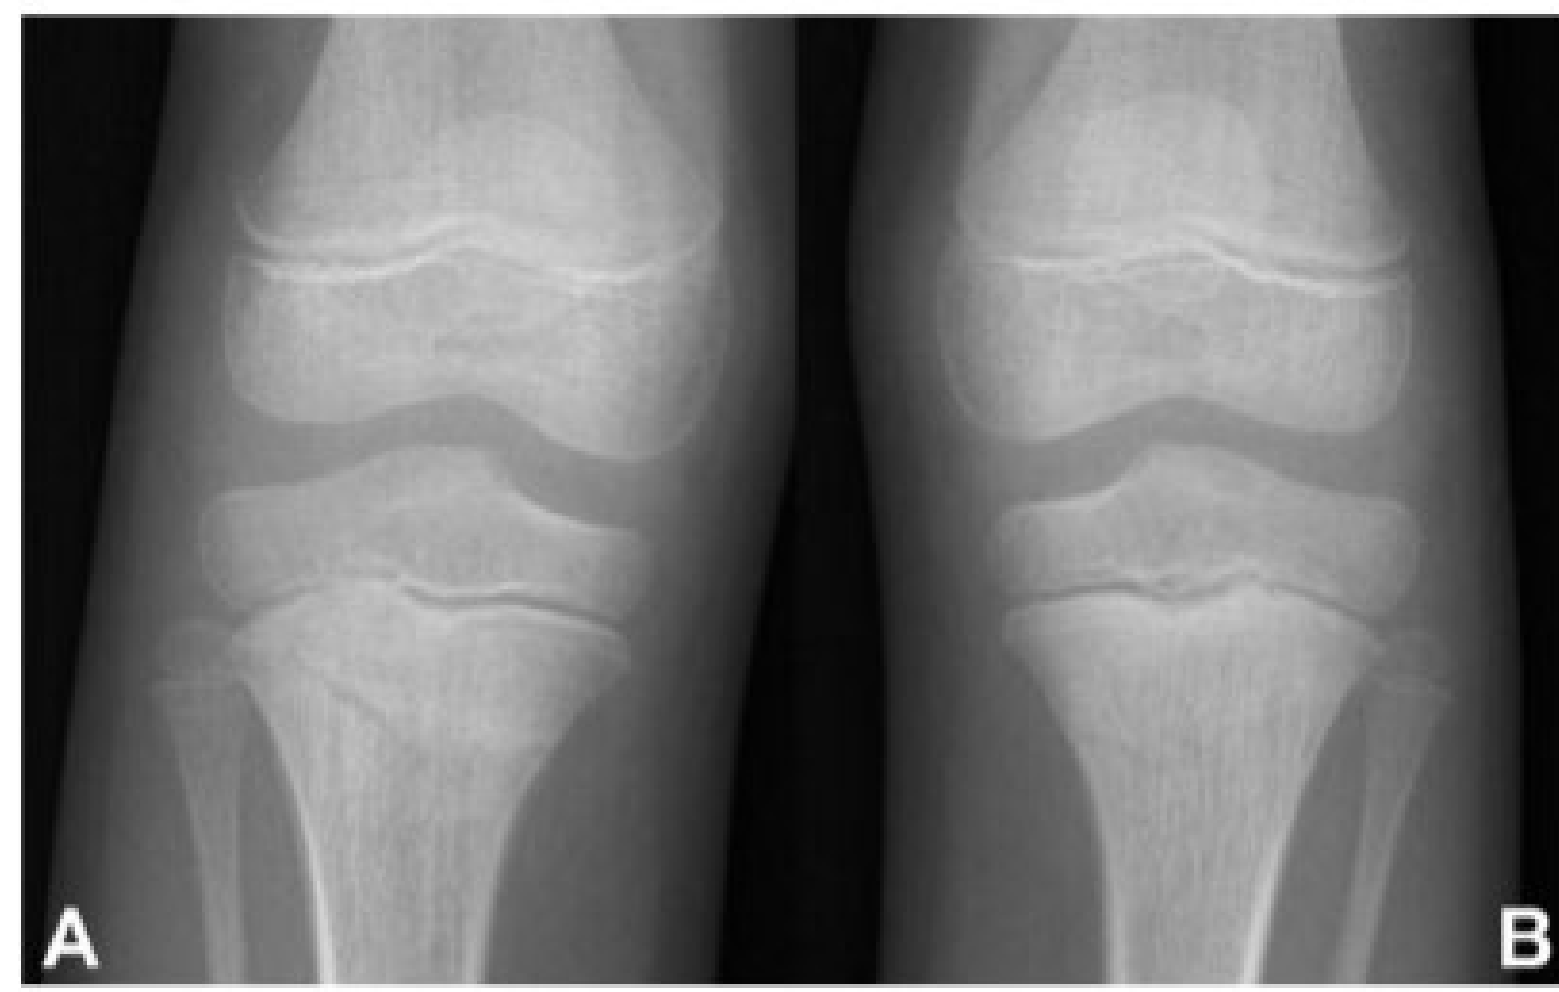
Anteroposterior radiographs of the right (A) and the left (B) knees at 5 weeks’ follow-up show linear sclerosis in both proximal metaphyses, with a significant blurring of the fracture lines.
